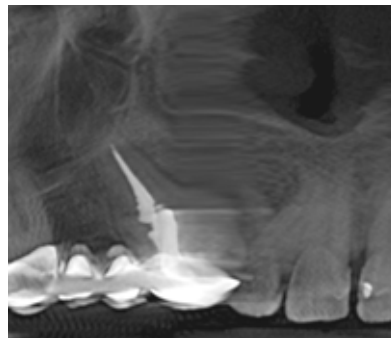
Detail out of the “implant view” in a CBCT. Considerable blurring due to patient movement
